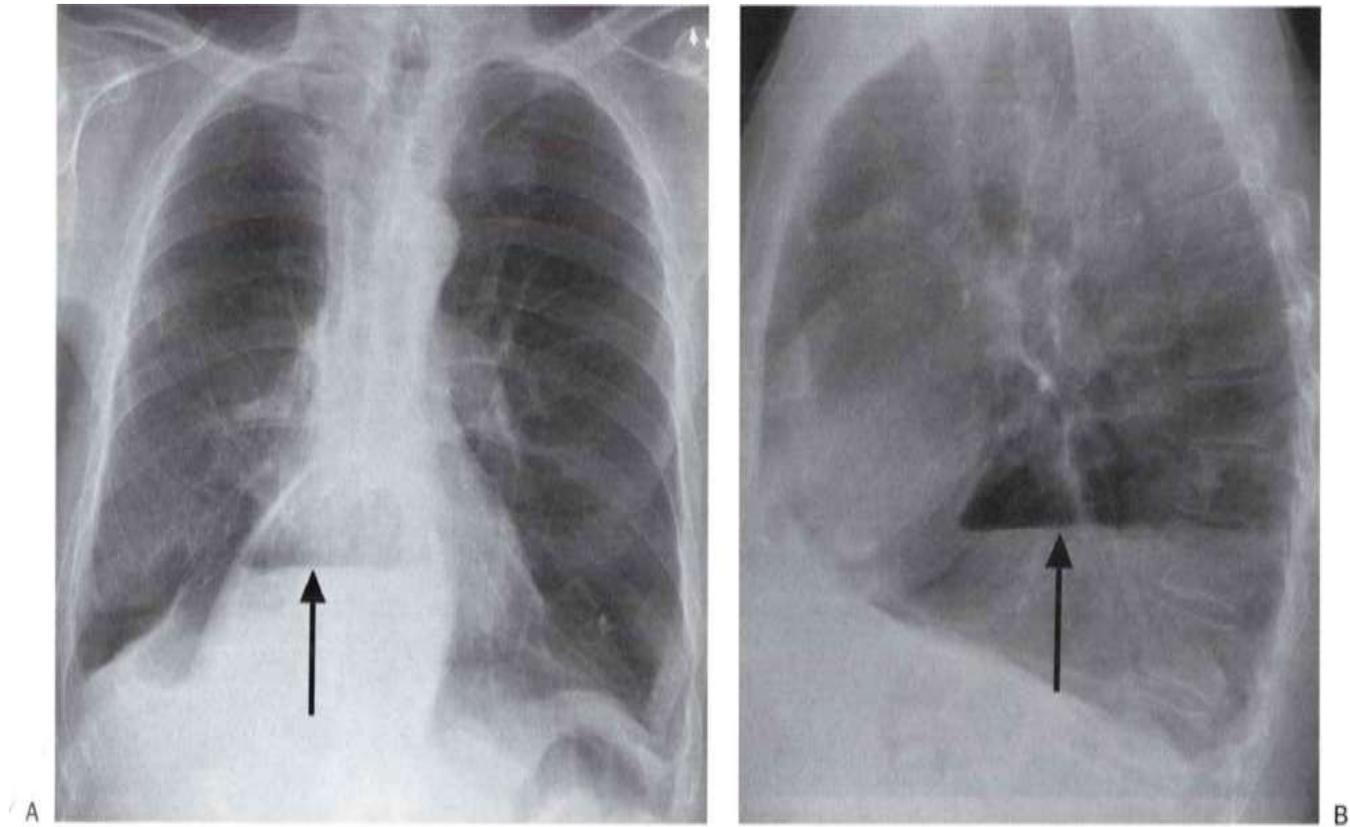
Hiatal hernia. A: PA chest radiograph shows a mediastinal mass containing an air-fluid level (*arrow*). B: Lateral view confirms herniation of stomach through the esophageal hiatus and again shows an air-fluid level (*arrow*).
